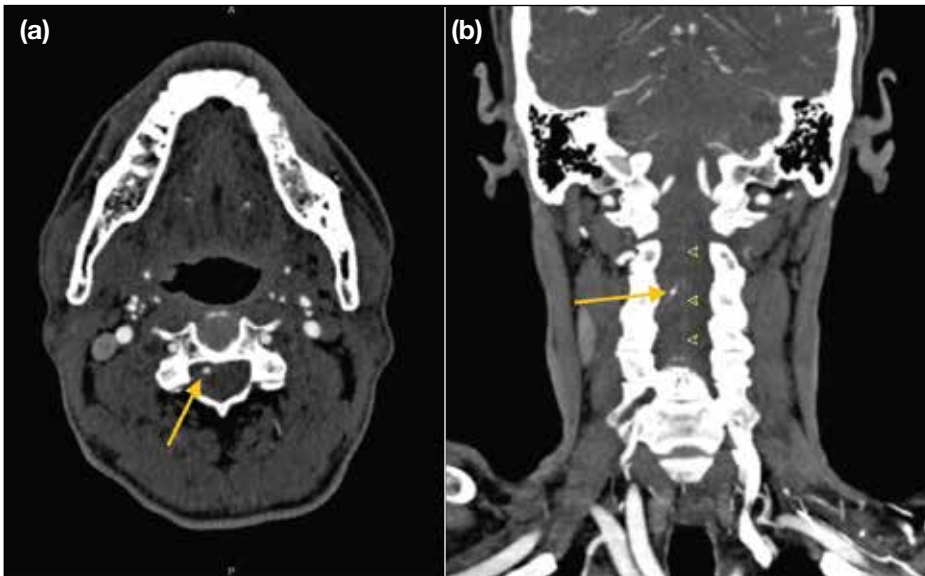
Computed tomography angiogram of the head and neck in axial plane (a) and coronal plane (b) showing tiny arterially enhancing lesion (arrows) in the cervical spinal canal at the C2/3 vertebral level arising from a branch of the right vertebral artery and connecting to the later catheter angiography-confirmed anterior spinal artery (arrowheads in [b]).
